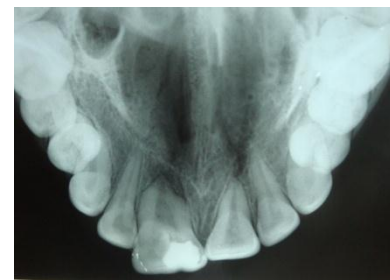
standard occlusal radiograph of maxilla
